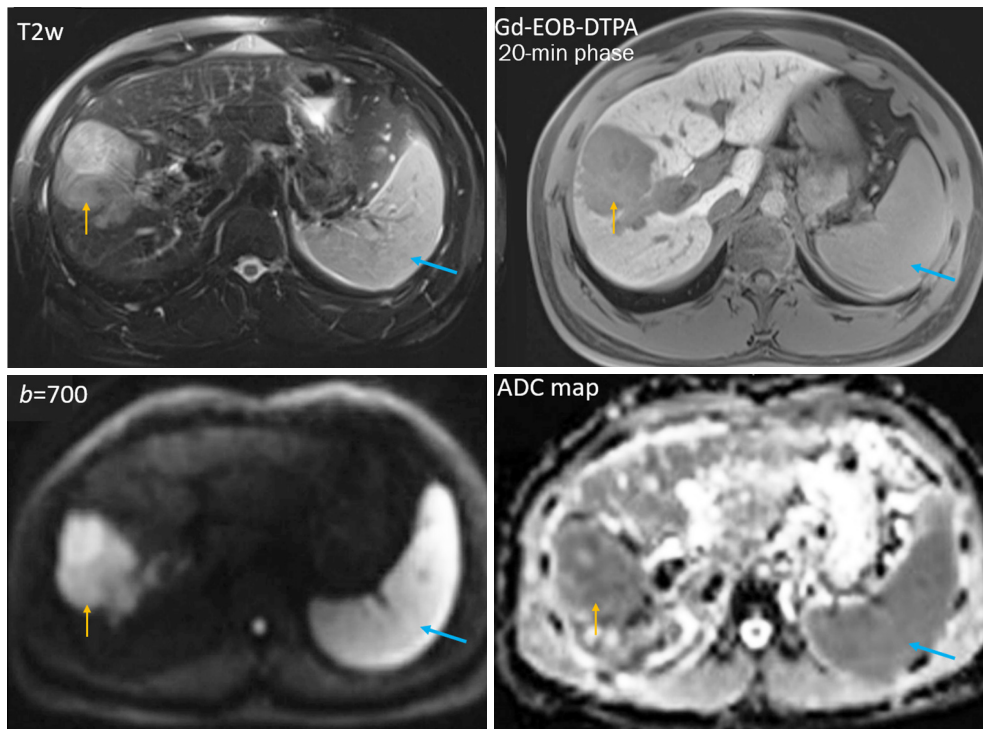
T2w, T1-weighted Gd-EOB-DTPA enhanced 20-minute hepatobiliary phase, diffusion weighted ($b=700 \text{ s/mm}^2$) MR images, and ADC map of the liver, a hepatocellular carcinoma (orange arrow) and the spleen (blue arrow). Though the tumor has heterogeneous structures, it appears that the tumor and the spleen show many signal similarities on these four images, with lower ADC value for the spleen and the tumor than for the liver. The lower spleen ADC value than the liver ADC value is likely due to a quantification error as described in this letter. Reproduced from Cao *et al.* (17). T2w, T2-weighted; Gd-EOB-DTPA, gadolinium ethoxybenzyl diethylenetriamine pentaacetic acid; ADC, apparent diffusion coefficient; MR, magnetic resonance.
